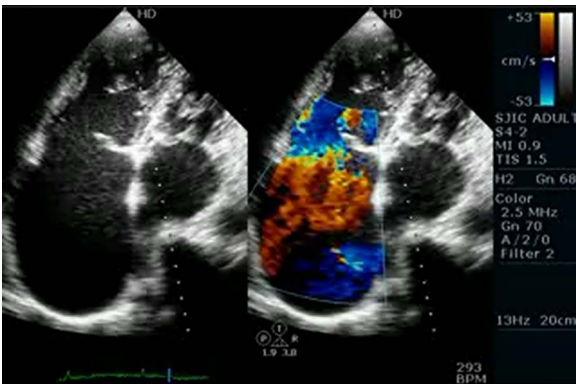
(A) Image showing elevated jugular venous pulse (JVP) in the anterolateral view. (B) Image showing elevated JVP in the lateral view. (C) Chest X-ray posteroanterior view showing cardiomegaly, right ventricular (RV) apex, dilated right atrium (RA) and pulmonary artery (PA). (D) Transthoracic echocardiography showing non-coapting tricuspid leaflets with severe tricuspid regurgitation (TR).
